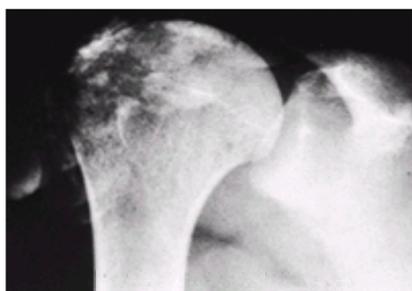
Radiograph of the shoulder of a young patient with renal osteodystrophy shows extensive calcification in the deltoid muscle, which has caused severe limitation of movement. Because of the radiographic projection, most of the calcification projects over the humeral head.
